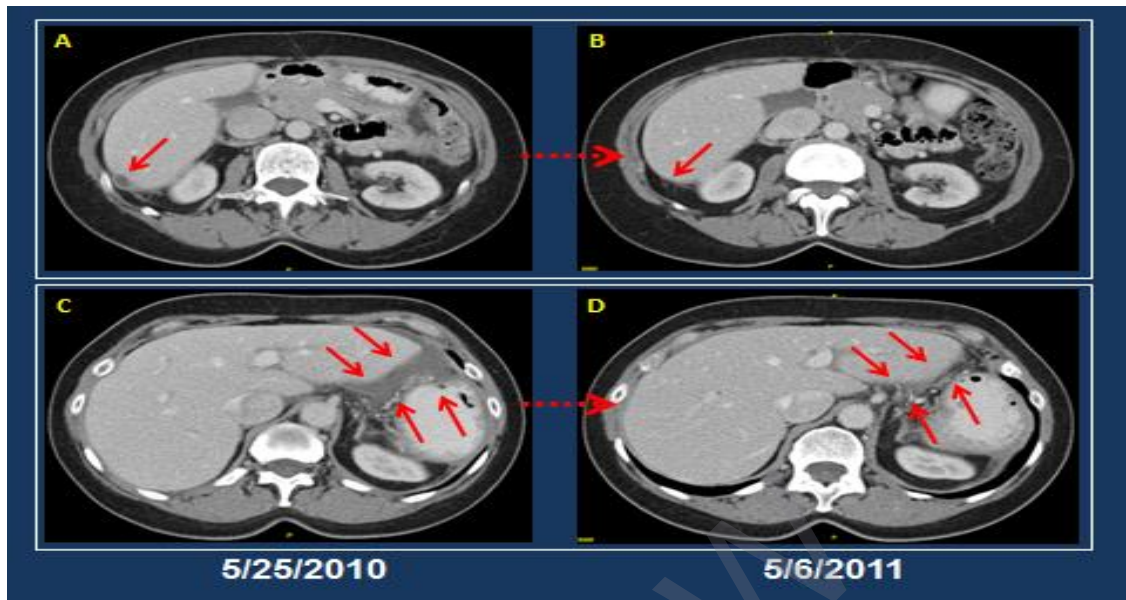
A 64 year-old female patient, treated for peritoneal metastasis: A and C: CT upper abdomen before taking Protandim[®] that showed 2 areas of peritoneal fluid/metastasis; B and D: CT upper abdomen 12 months after taking Protandim[®] that the two areas were significantly decreased in size (near complete response).
